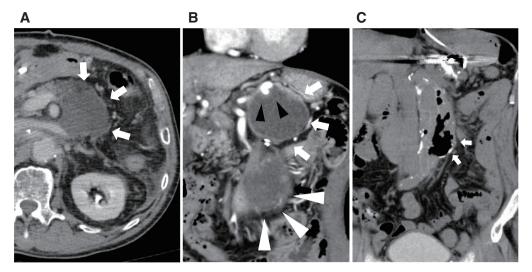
Preoperative CT findings. (A) Seven days after open graft replacement for a ruptured AAA. White arrows show the pancreatic pseudocyst. (B) CT image 2 months postoperatively demonstrates the splenic artery aneurysm (black arrowheads), enlargement of the pseudocyst (white arrows), and enlargement of the perigraft sac (white arrowheads). (C) Air in the perigraft cavity was observed on the CT image the next day after endoscopic ultrasound-guided pancreatic pseudocyst drainage. AAA: abdominal aortic aneurysm; CT: computed tomography
